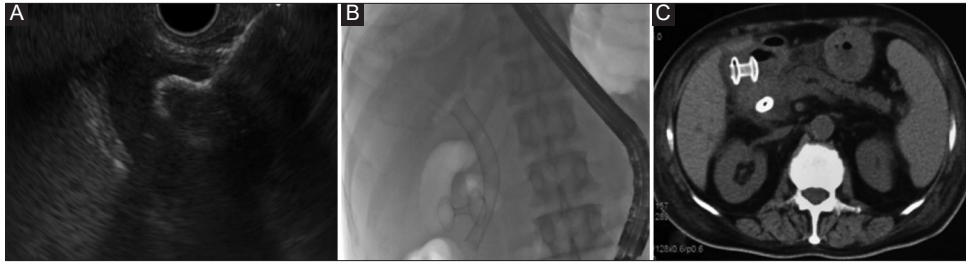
EUS guided cholecysto-duodenostomy for acute cholecystitis in a patient with pancreatic adenocarcinoma and cystic duct obstruction. (A) Inner flange of cauterized LAMS placed inside the gallbladder lumen. (B) LAMS deployed. (C) CT abdomen showing deployed LAMS with one flange in the gallbladder and the other flange in the duodenum
